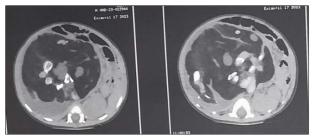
Abdominal CT scan showing a large compressive mass with osseous structures suggestive of a teratoma.
